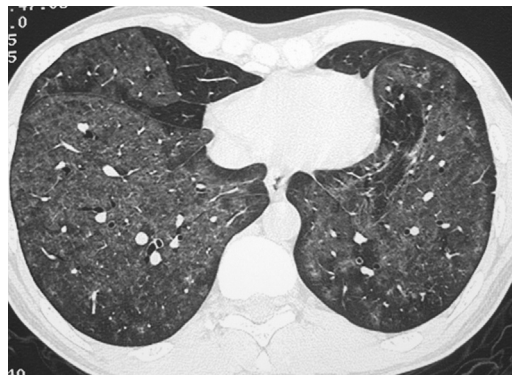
Pneumocystis jiroveci* pneumonia. CT shows extensive bilateral and homogeneous ground-glass opacities. Bronchoalveolar lavage showed *P jiroveci*.
